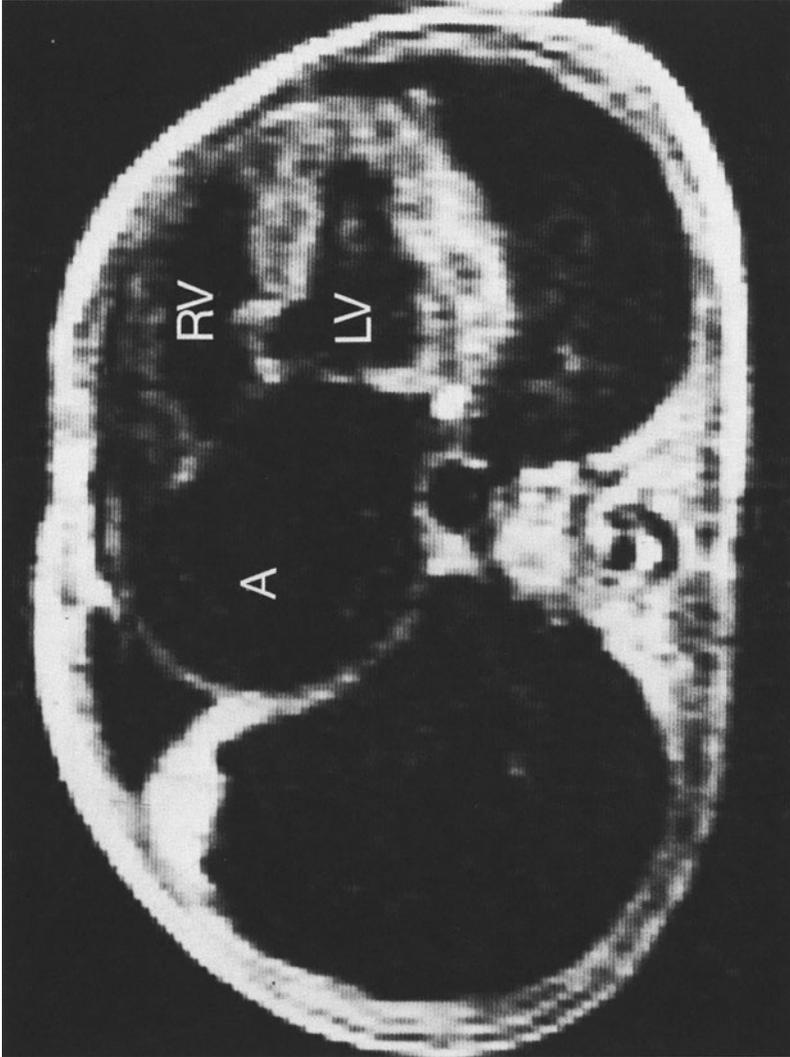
Transverse MRI view in a patient with common atrium. Although the ventricular septum is well seen, no atrial septum is visualized. *A* = common atrium, *LV* = left ventricle, *RV* = right ventricle.
